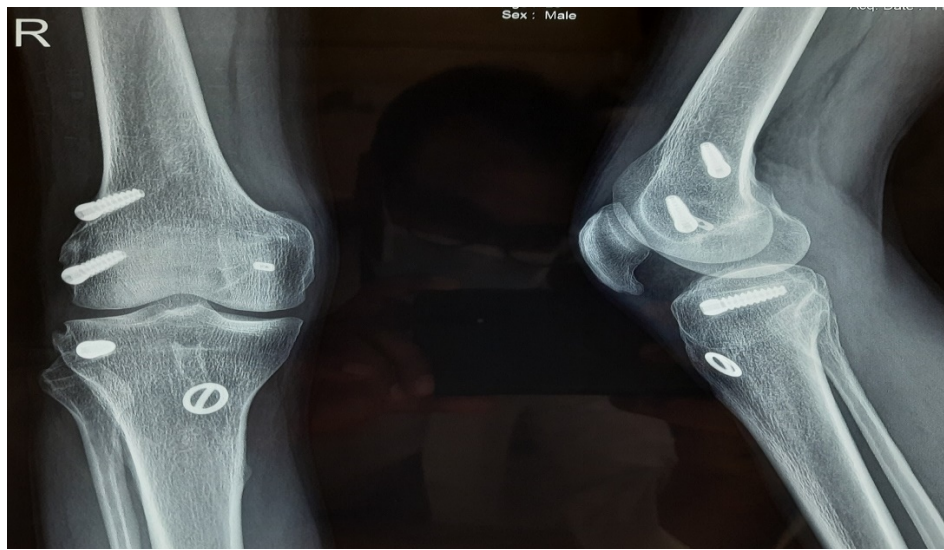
Postop X-Ray (1 Year Follow Up)
